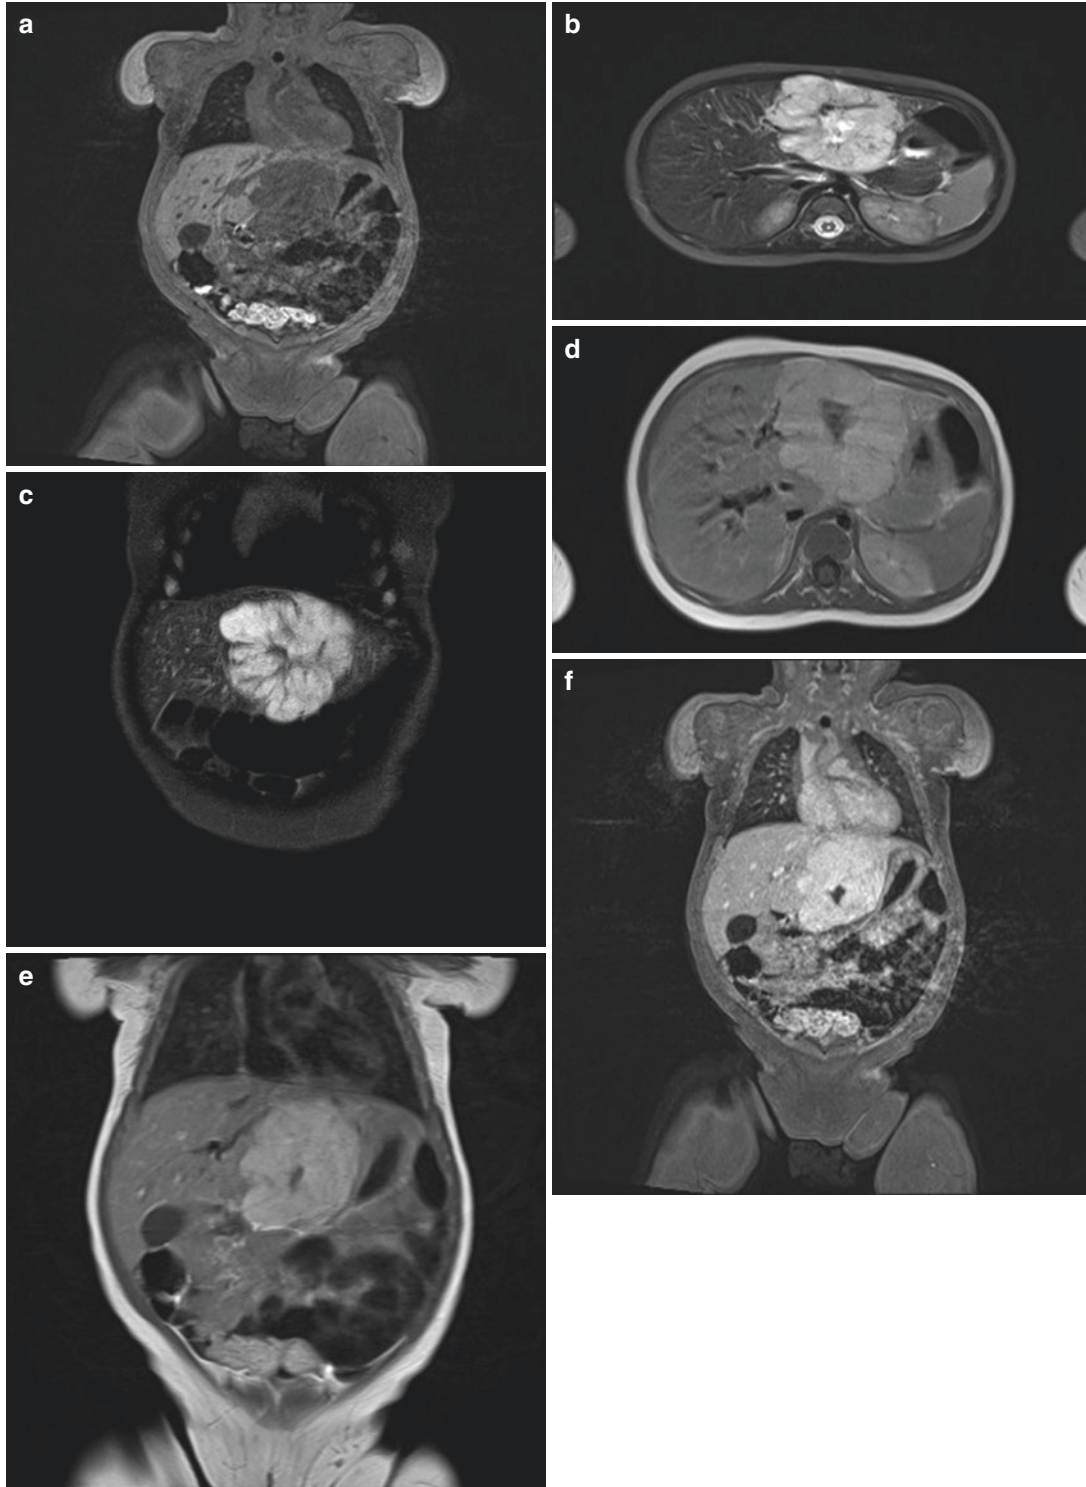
(a–f) MRI of FNH—There is a large lobulated lesion in the left lobe of liver which is iso to hypo intense to liver on T1WI (a), predominantly hyper intense periphery with hypo intense central scar on STIR
